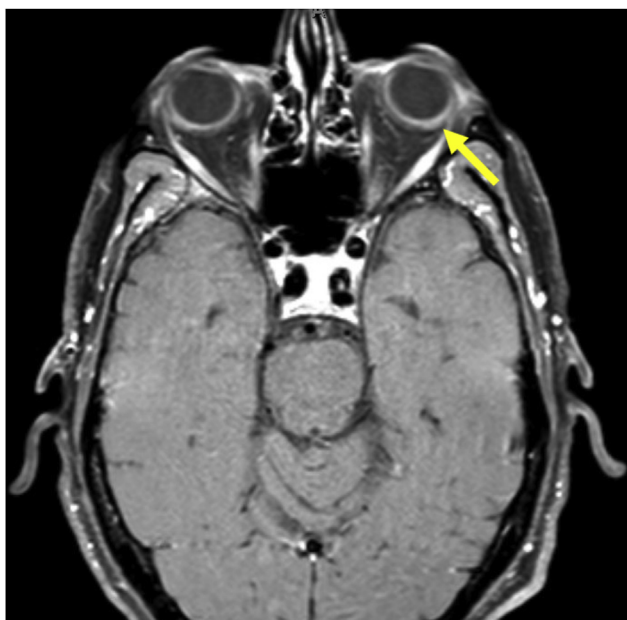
Post-treatment T1-weighted MRI of the orbits taken approximately one year after treatment, showing continued resolution of the lesion (arrow).
